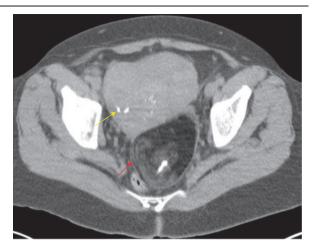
Axial CT left ovarian mass (red arrow) containing fat and calcification 9 years earlier. Mass is causing rightward displacement of the uterus, which contains calcified fibroids (yellow arrow).
